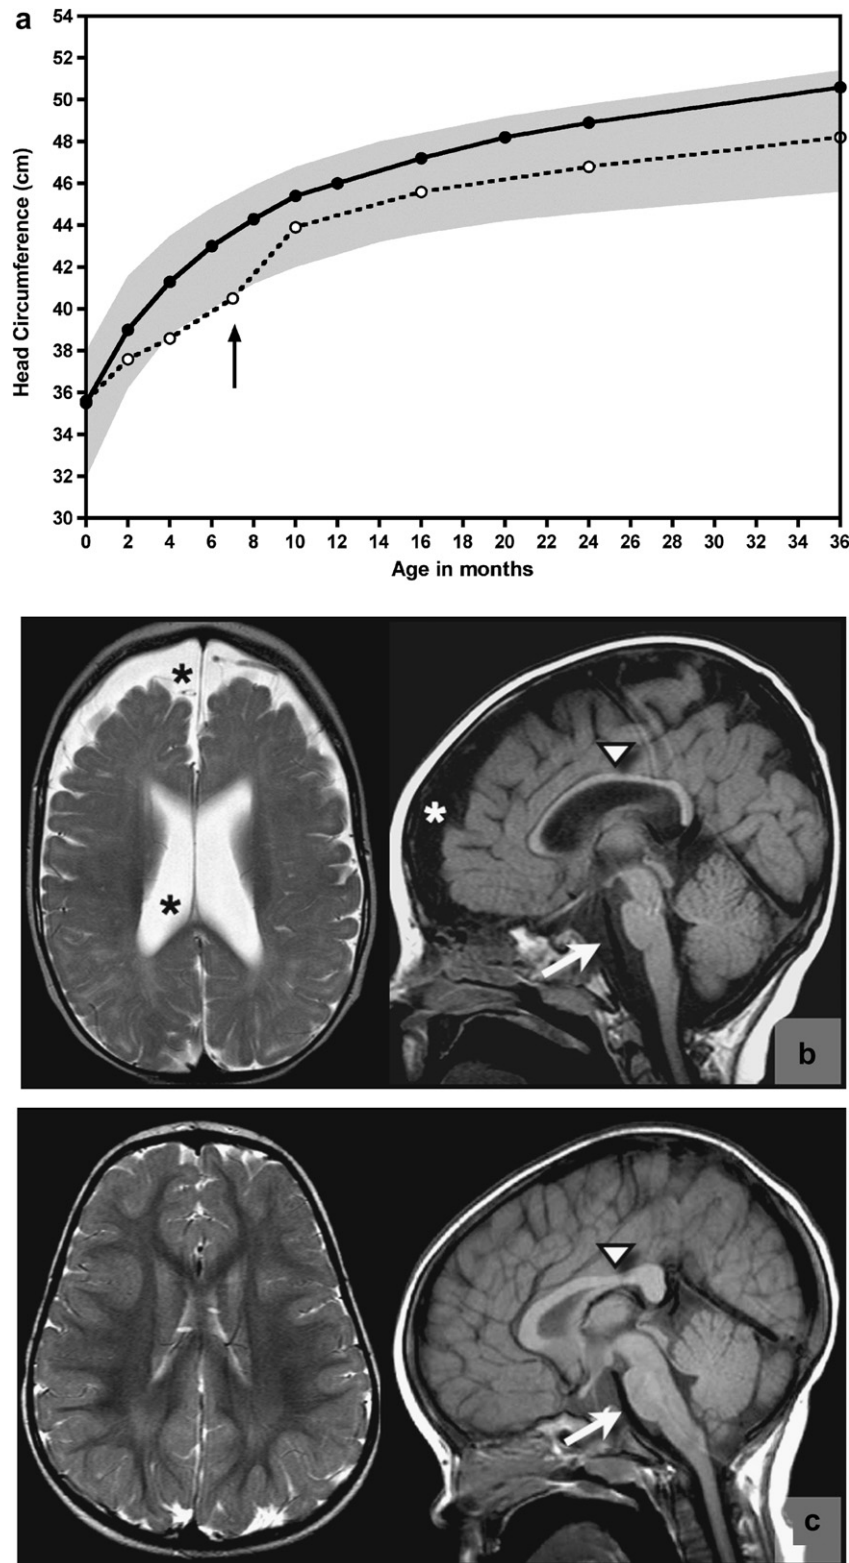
Patterns of brain growth in Amish children with MTHFR deficiency. (a) Brain growth, as indicated by change in head circumference, for one child who started betaine therapy (arrow) at 7 months of age (dashed line), and one who started betaine therapy at 16 days of age (solid line). Increased head growth on betaine therapy was seen in infants who started betaine at 7 and 13 months of age, but not in those who started treatment at 4 and 18 years of age. The shaded area represents the normal range (± 2 standard deviations) for head size from birth to age 36 months. (b) Axial and sagittal T2-weighted MRI of a 14 month-old patient prior to the start of therapy show large ventricular and extra-axial fluid spaces (asterisks) secondary to global brain atrophy. The spinal cord, brainstem (arrow), and corpus callosum (arrowhead) are thin, secondary to poor neuron growth and hypomyelination. (c) Comparable images (obtained at age 18 months) from a child who began taking betaine during the newborn period show a fully developed and appropriately myelinated brain.
